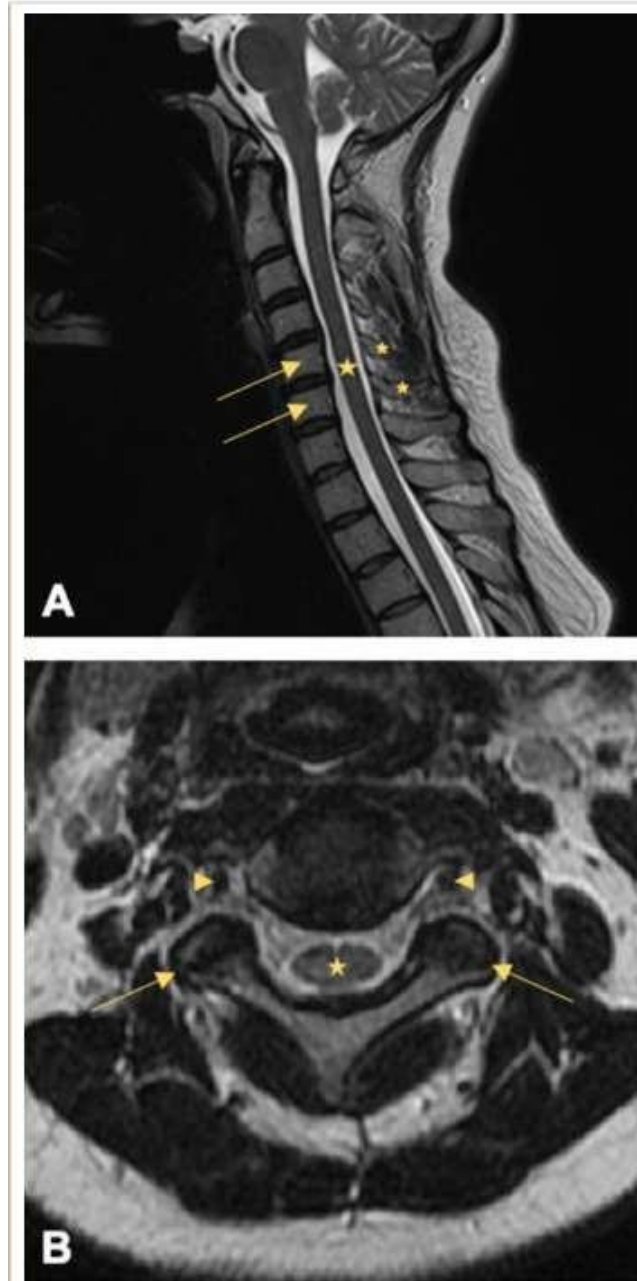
A T2-weighted MRI of the cervical spine demonstrates the C1-C7 vertebral bodies (indicated by arrows), spinous processes (asterisks), and spinal cord (star) within the spinal canal in the midsagittal view (A). The axial view highlights the facet joints (arrows), transverse processes and foramina (arrowheads), and a cross-section of the spinal cord (star; B).
